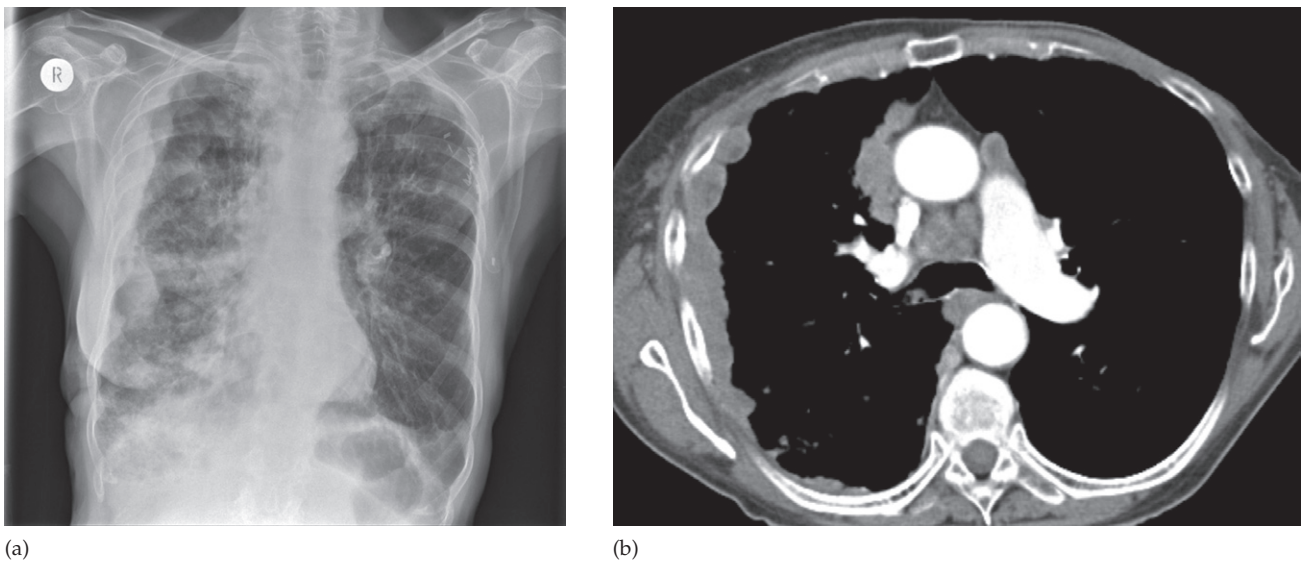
Metastatic disease of the pleura. (a) CXR and (b) CT in a patient with breast cancer showing diffuse thickening of the pleura on the right, secondary to metastatic disease. Note the absence of the left breast shadow due to a previous mastectomy on the CXR.
